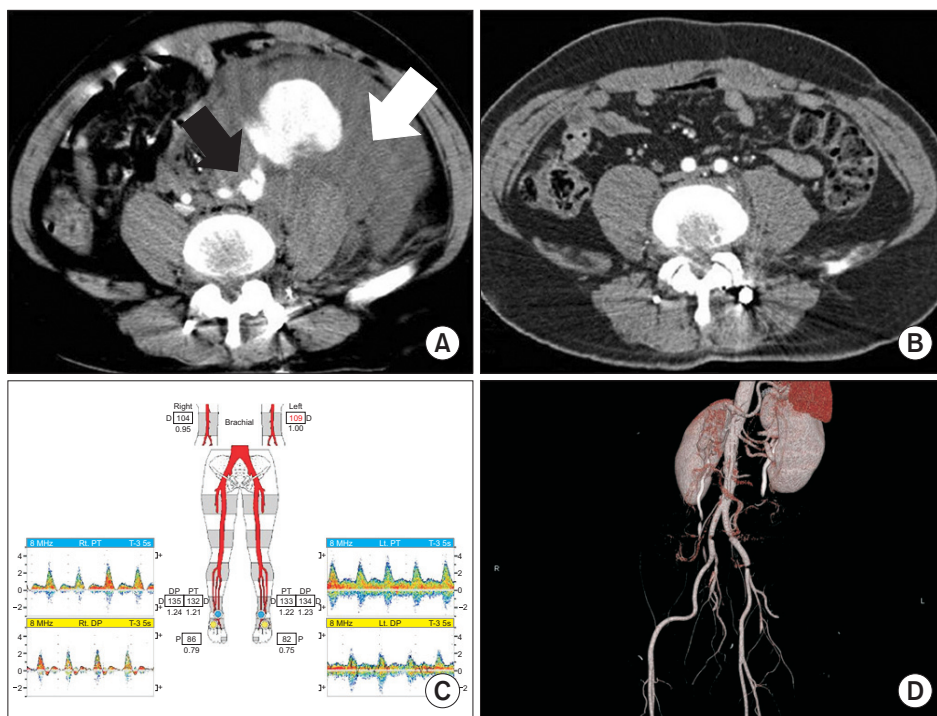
(A) After discectomy, computed tomography (CT) shows hematoma in retroperitoneum (white arrow) and extravasation with a leakage of dye at the left common iliac artery (CIA) (black arrow). (B) After exploration and primary repair of the left CIA, CT shows no evidence of extravasation and aneurysm. (C) Fifteen years after surgery, follow-up vascular lab finding shows no evidence of abnormal finding. (D) Also CT angiography shows no evidence of abnormal finding. PT, posterior tibial; DP, dorsalis pedis.
